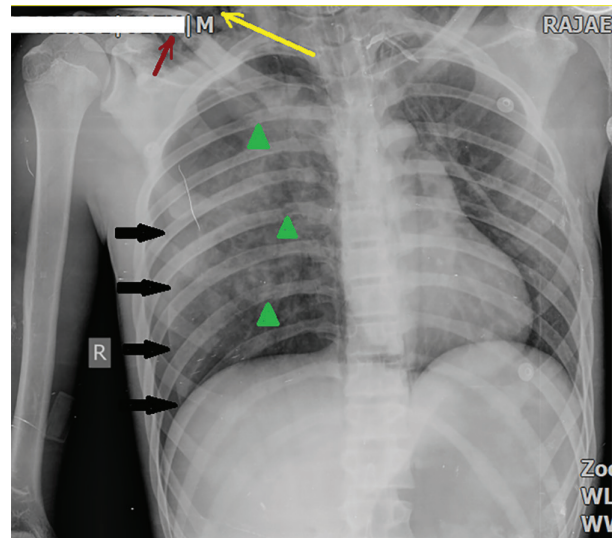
First PA Chest X-ray shows right-sided pneumothorax (black arrows), rib fractures (green arrows), subcutaneous emphysema (yellow arrow), and clavicular fracture (brown arrow).
